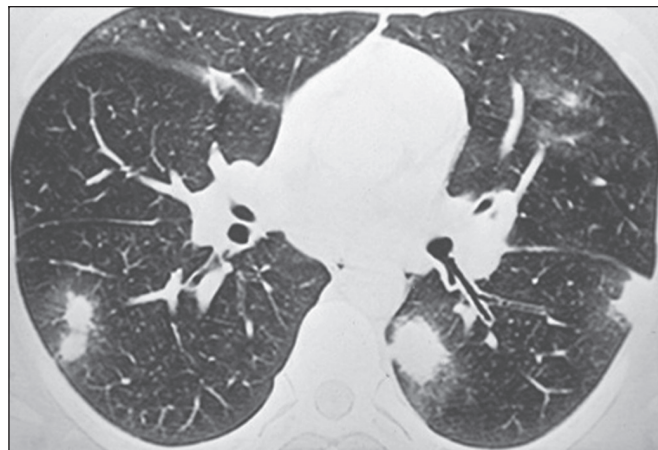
CT of a 47-year-old woman, showing multiple nodules of varying sizes with ground-glass halos in both lungs.
